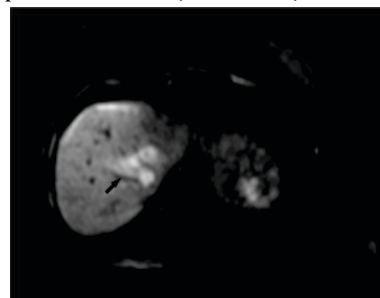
MRI Diffusion Imaging Showing Restriction in the Liver Lesions
